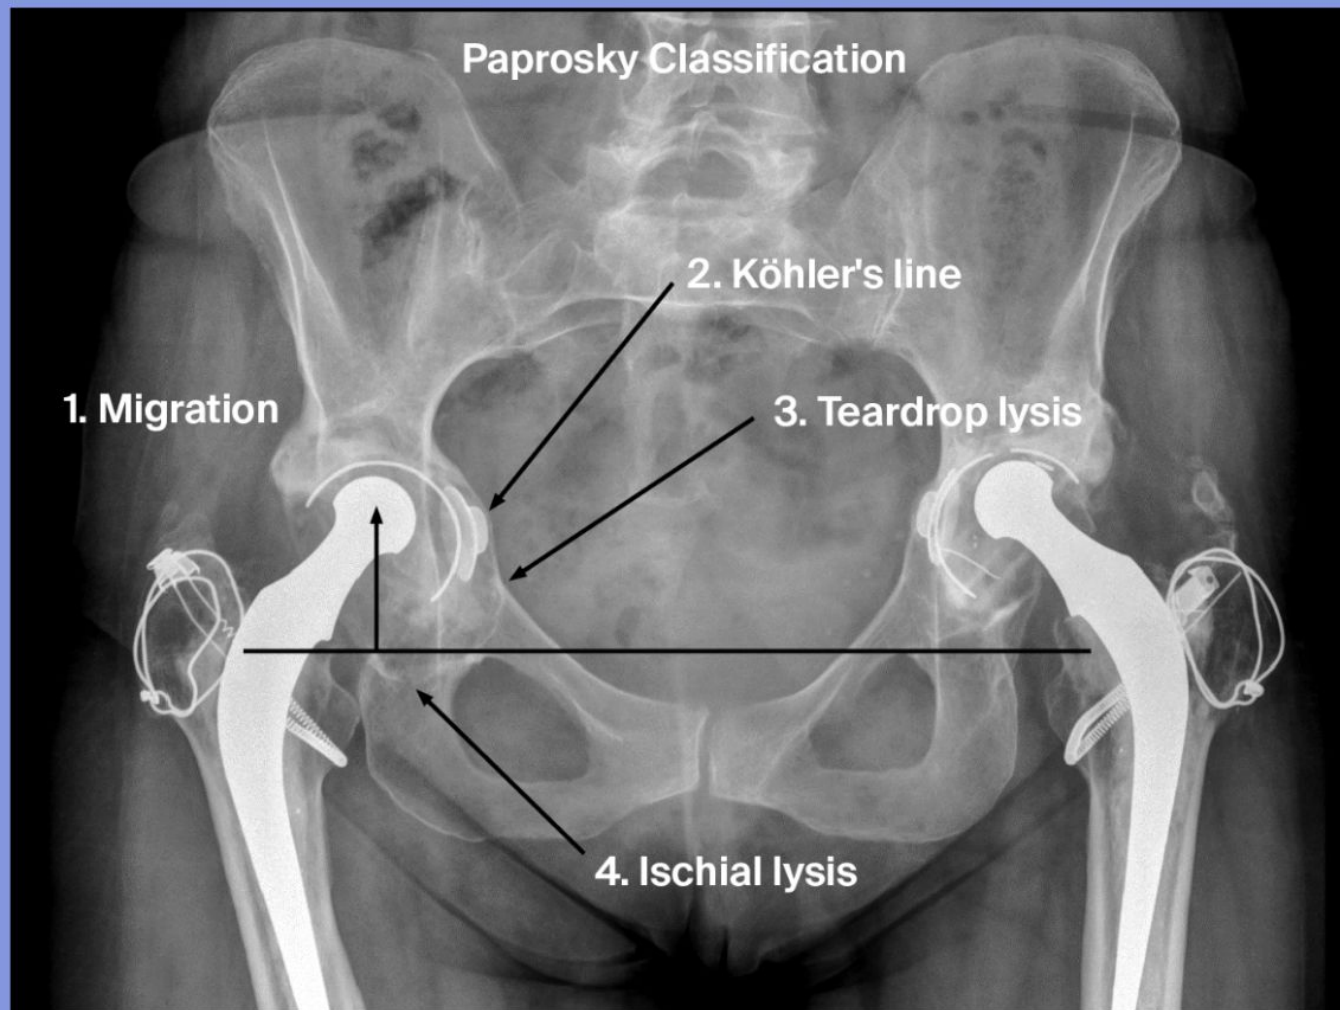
Radiographic features of Paprosky Classification (Courtesy of George Macheras)
